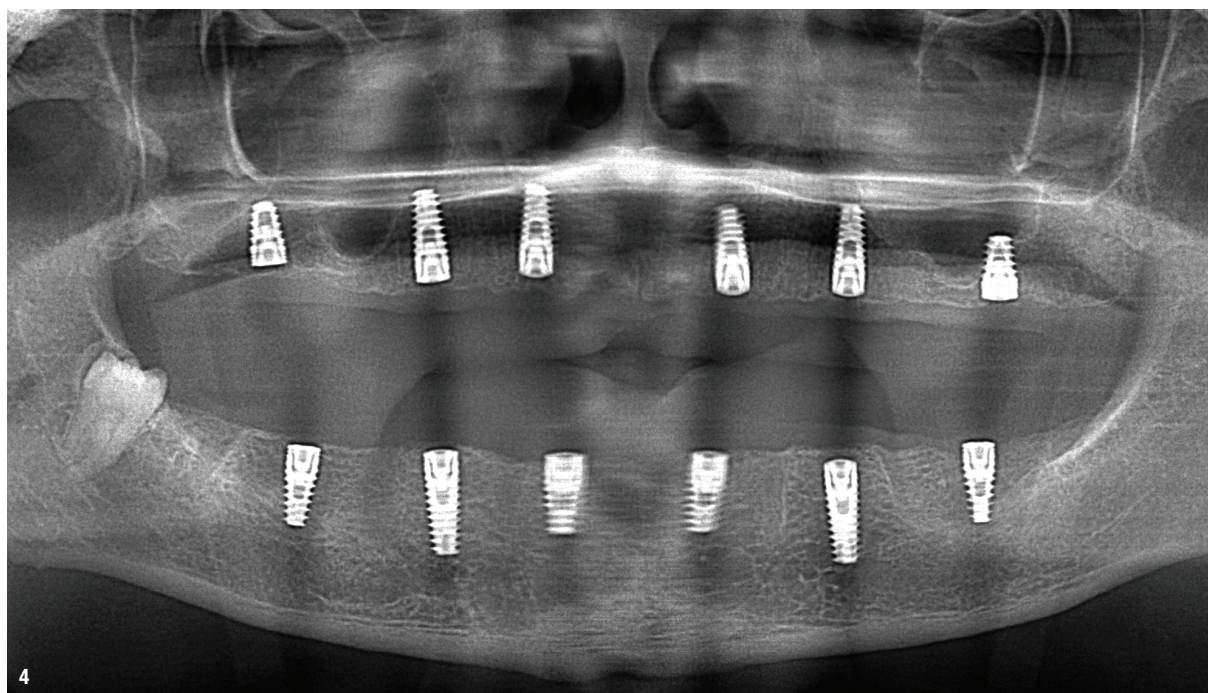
Radiographic examination four months after implant placement.
